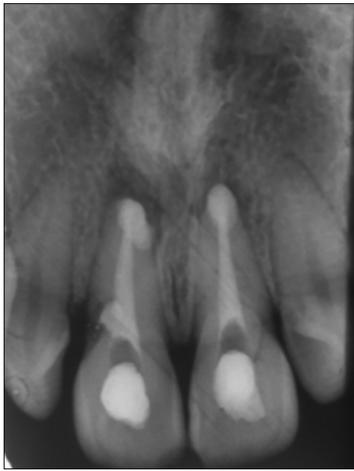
Follow up radiograph at 2 weeks
